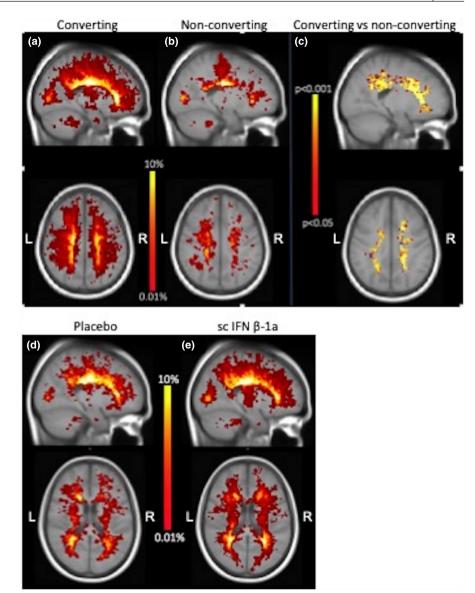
Abbreviations: CDMS, clinically definite multiple sclerosis; EDSS, Expanded Disability Status Scale; FCDE, first clinical demyelinating event; Gd+, gadolinium-enhancing; IFN, interferon; LPM, lesion probability map; MRI, magnetic resonance imaging; Q, quartile; sc, subcutaneous; SD, standard deviation.
